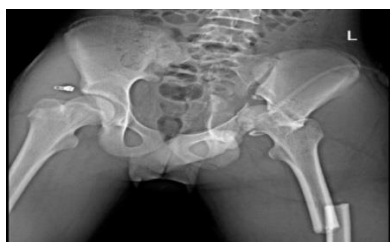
Preoperative anteroposterior (AP) radiograph of the pelvis
